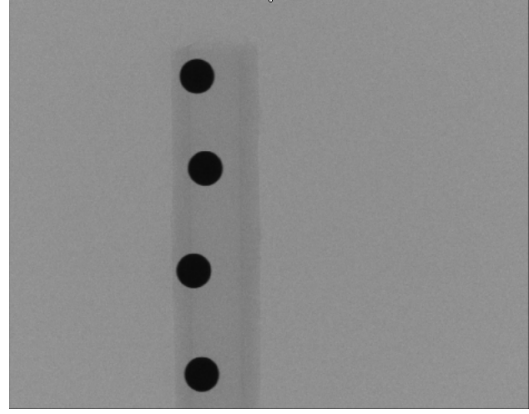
X-ray projection of the four ball pen balls on a hollow plastic rod sample. The balls have a diameter of 1mm.
